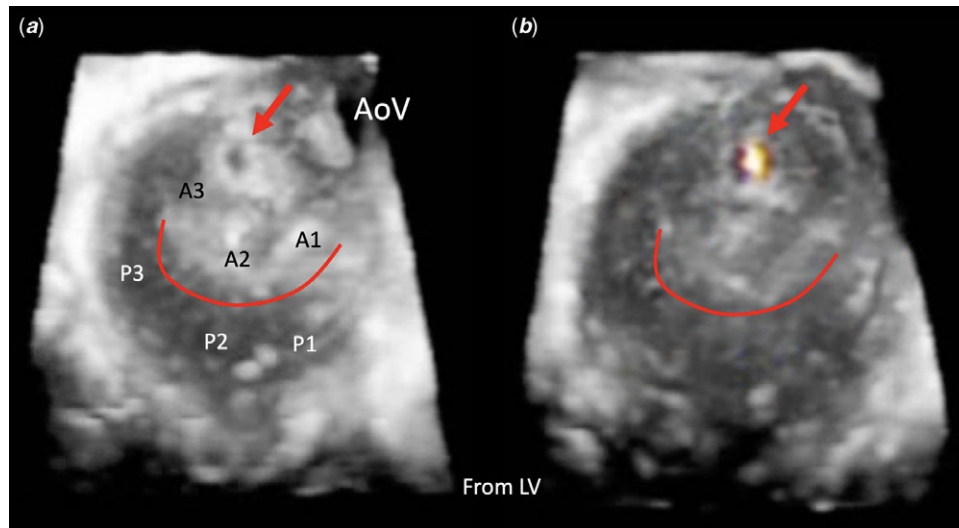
(a) Three-Dimensional reconstruction of the mitral valve as viewed from the left ventricle (LV) in systole. The scallops (A1-3, P1-3), aortic valve (AoV) and zone of apposition (red line) are labelled. The perforation is marked with the red arrow. (b) Color Doppler signal is seen as the origination of the regurgitation jet. The perforation is marked with the red arrow.
